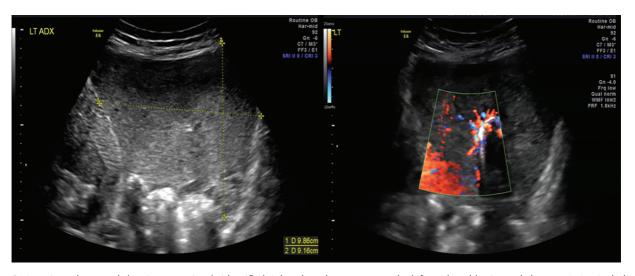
Inpatient ultrasound showing a previously identified right adnexal mass now on the left, with stable size and characteristics, including prominent vascularity.
